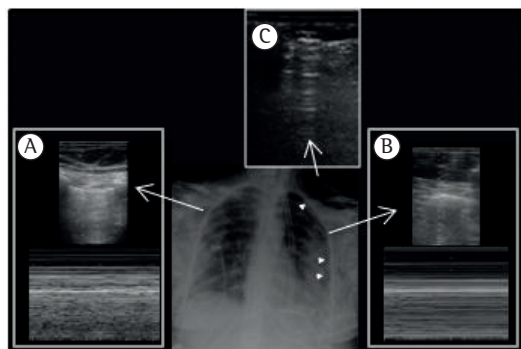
Ultrasound signs of pneumothorax. In A, normal lung, showing the seashore sign in M mode. In B, pneumothorax, showing the stratosphere sign in M mode. In C, subcutaneous emphysema. Arrowheads indicate the pneumothorax.
